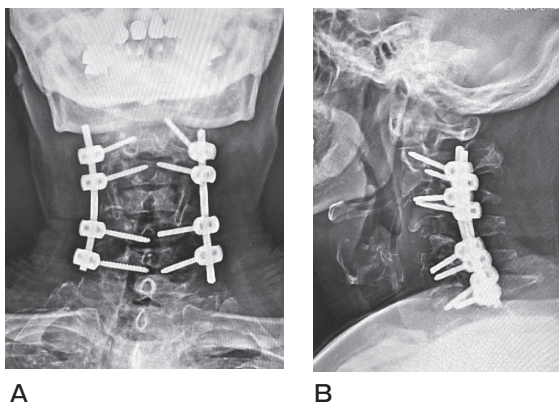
Final follow-up radiographs. Final follow-up radiographs (at 2 years and 6 months postsurgery) show good spinal balance and no neurological deficit.
